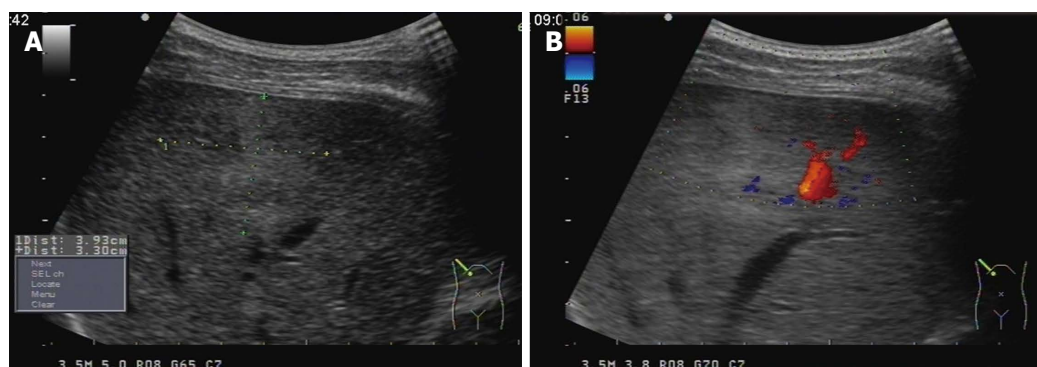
B-mode ultrasonography. A: B-mode ultrasonography showing a 3.9 cm × 3.3 cm mass with inhomogeneous echo in the right hemiliver; B: The boundary was unclear and some blood-flow signal was detected within the mass.
